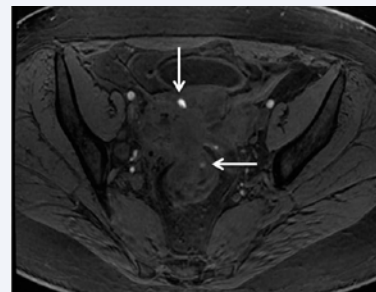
CT after contrast administration, pelvic imaging, parauterine sample mass [arrows] with utero-rectal and parametrial affection, responsible for the hydronephrosis by ureteral entrapment, Uterus (Star).
